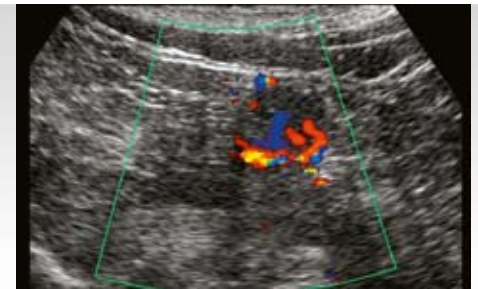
a and b: The tumor was isoechoic to the surrounding cortex and mainly identified due to the mass effect (Fig. 4 a). Large vessels were detected within and around the tumor at color Doppler US (Fig. 4 b).
